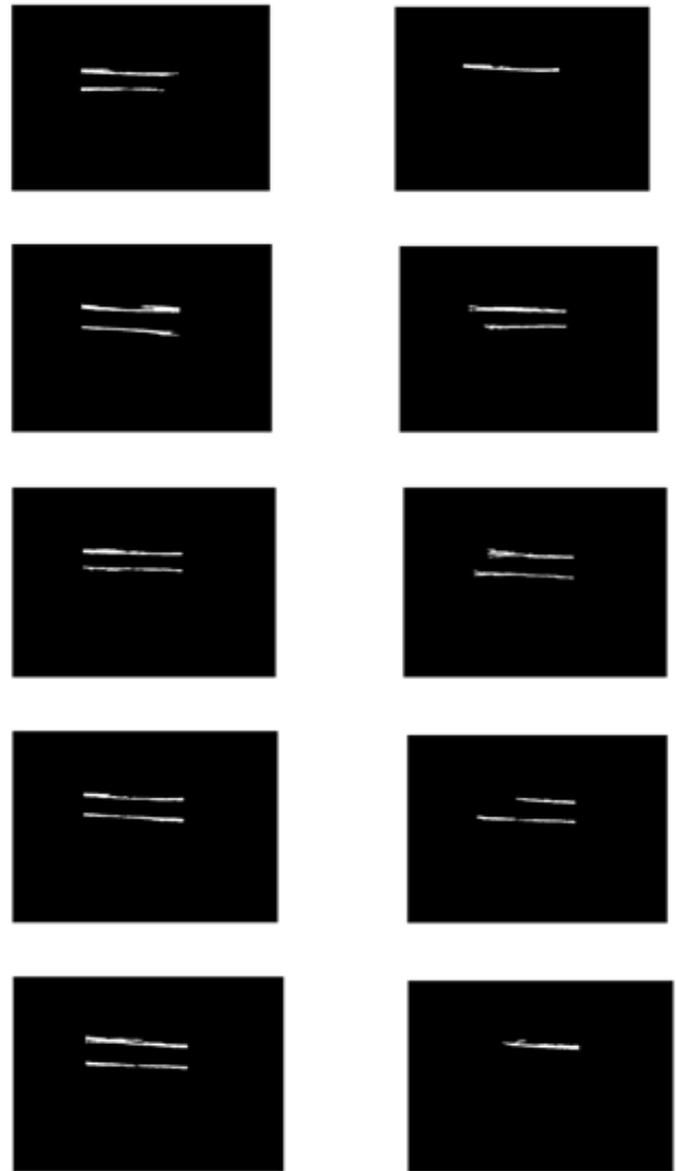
Results of 10 males carotid artery ultrasound images
